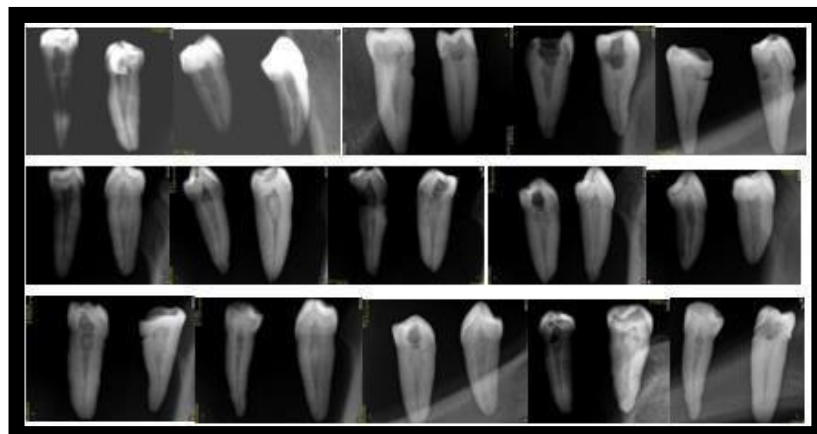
X-RAY FOR SINGLE CANAL CONFIRMATION
